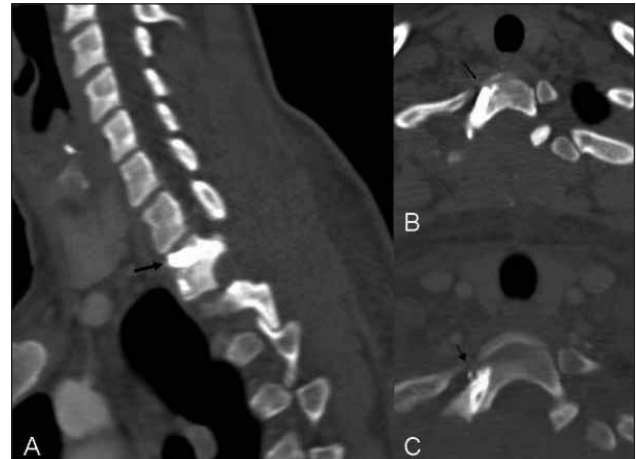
Thoracic axial CT showed total removal of T1 lamina with hyperdensity due to bone cement in the corpus of the T1 vertebra (black arrow) (A), IV contrast (gadolinium) was given and no contrast enhancement was seen at the operational area (black arrows) (B) and (C).
